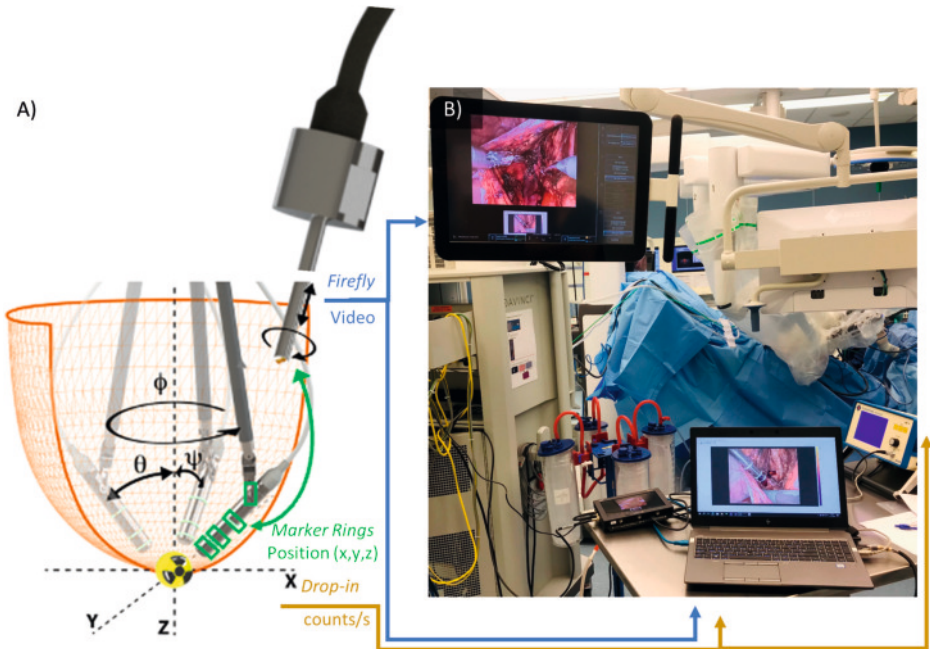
Technical set-up: A) Representation of the drop-in sensor maneuverability in a surgical cavity as monitored using the Firefly Xi endoscope (video tracking is used to segment out the green marker rings and estimate the position and orientation of the sensor tip). B) Visualization of RoboSPECT generation during surgery and augmented reality visualization of the RoboSPECT scan on a laptop and in the assistant display via tilepro (surgeon view is identical to that of the assistant). Drop-in out-/inputs in yellow arrows, Translation ring position to endoscope in green arrow, Video out-/inputs in blue arrows.
